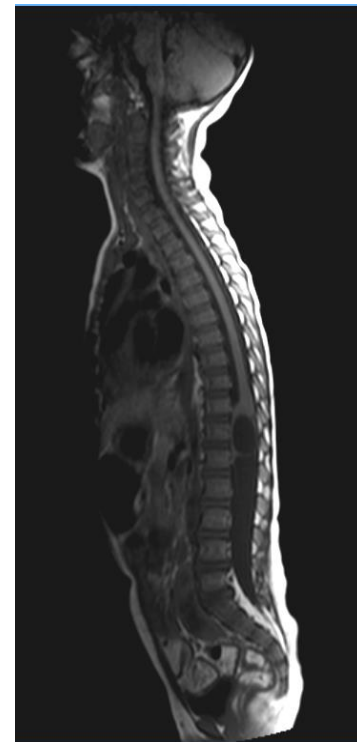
(A): sagittal T1 WI of spine MRI shows a hypointense well defined expansile intramedullary lesion at the conus medullaris .
